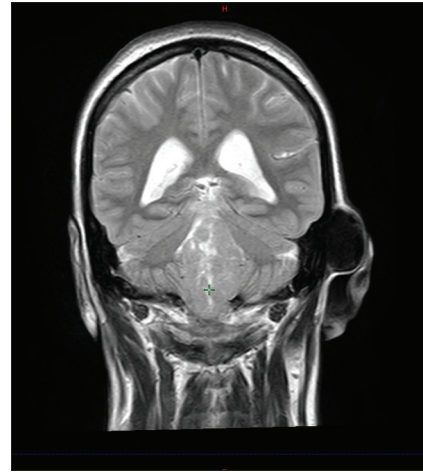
Magnetic resonance imaging T2 coronal image showing iso- to hyperintense tumor with proximal dilatation of the supratentorial ventricular system
